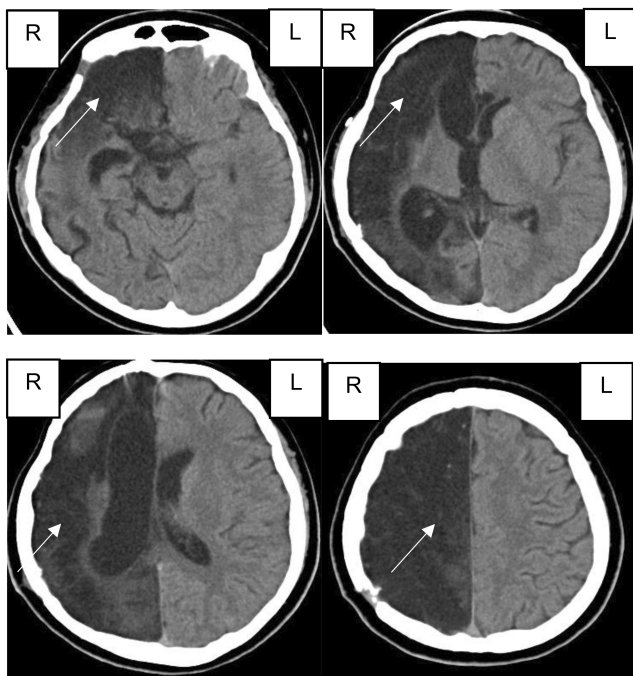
Brain computed tomography image for case 1 upon admission to the convalescent rehabilitation ward. Computed tomography images show extensive areas of low density in the right anterior, middle, and posterior cerebral artery regions (arrowheads).
